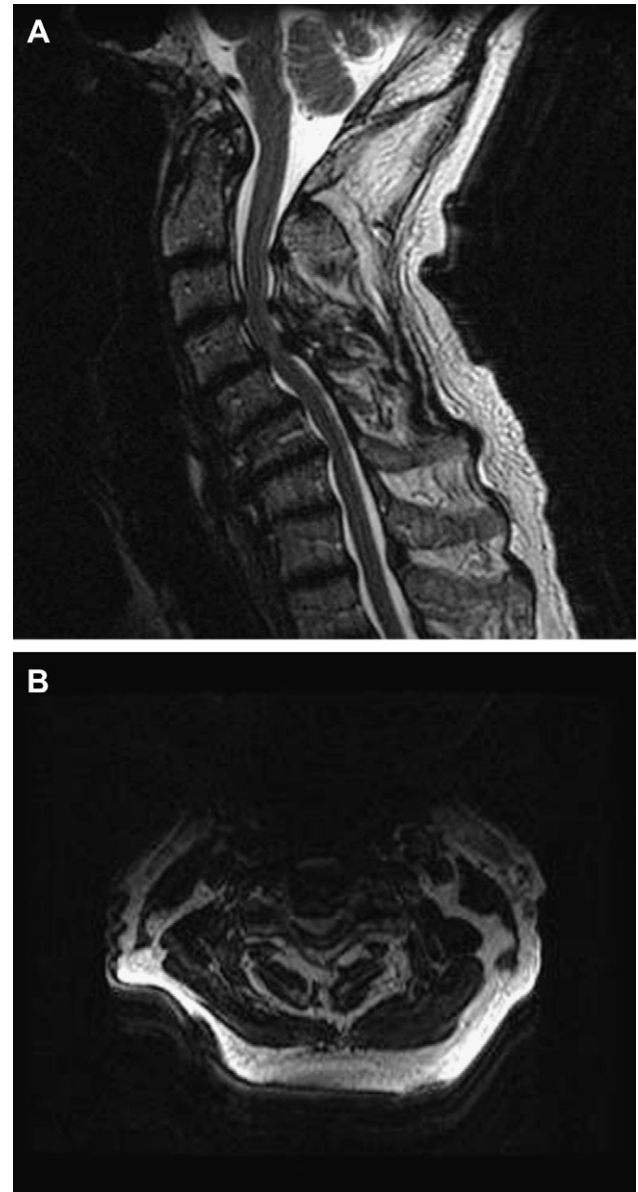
T2 sagittal (A) and axial (B) magnetic resonance imaging of a 75-year-old man who developed cervical myelopathy. Multilevel calcified disc displacement may be seen with associated hypertrophy of the posterior ligamentum flavum. The result is circumferential spinal cord compression.
